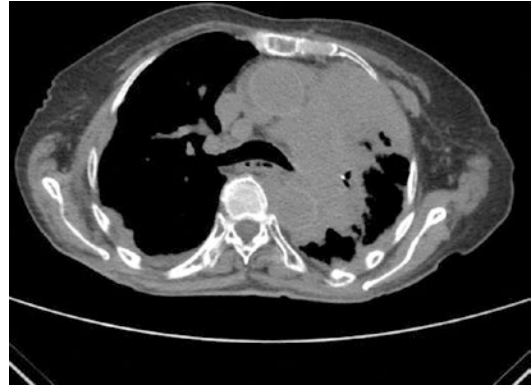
Axial CT section demonstrating extensive left-sided disease with tumor and compressive atelectasis; similar density between tumor and collapsed lung prevents clear demarcation of lung boundary and tumor margin
